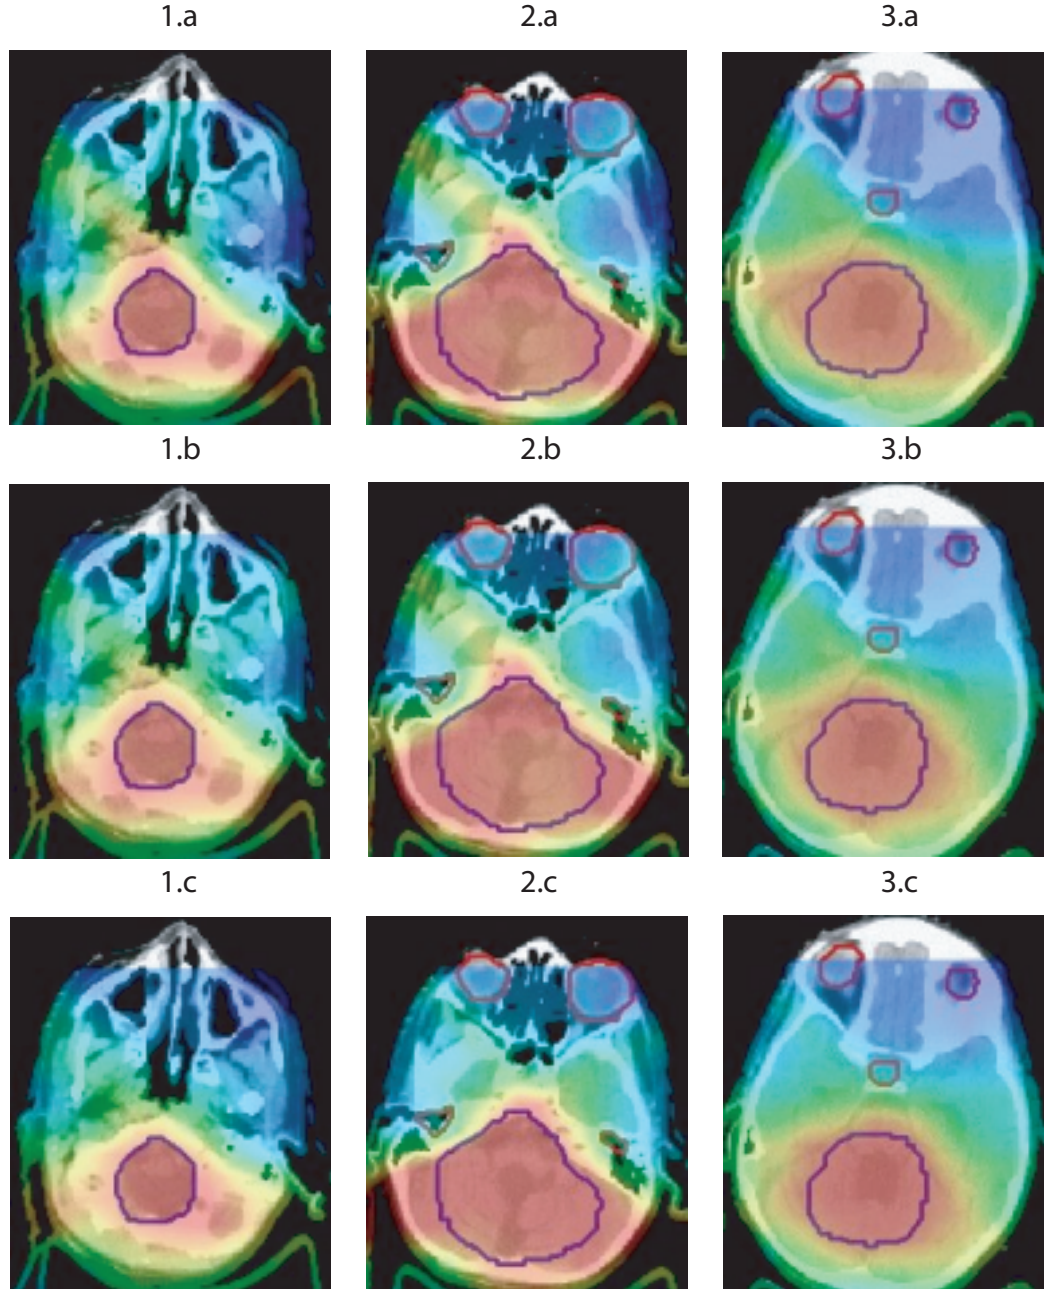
Brain Case Dose Distribution: (a) Basic 8 Equi-spaced Beams Solution, (b) Final 8 Equi-Spaced Beams Solution, (c) Final 8 Selected Beams Solutions are shown with a colorwash dose distribution overlaid with three CT axial images. The prescription dose is shown as red colorwash with 75, 50 and 25% of prescription dose shown as yellow, green and blue colorwash. CT axial images 1, 2, and 3 represent inferior, mid and superior slices through the target volume shown as a blue contour. The red contours represent the eyes. The cochlea structures are shown on slice 2 in red, and the pituitary is shown as red contour on slice 3.
